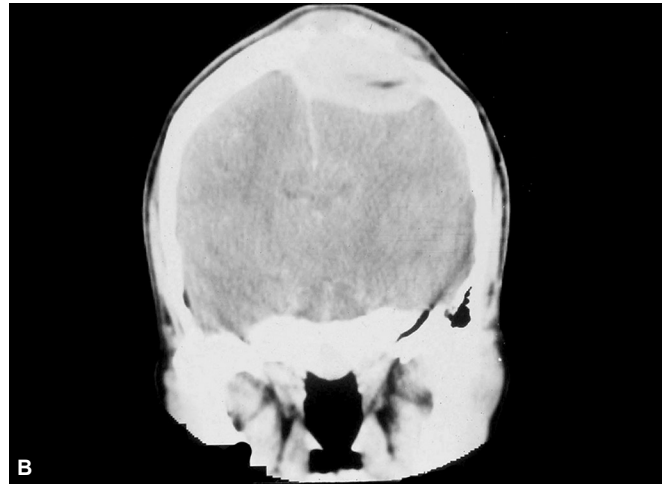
Growing fracture. Posteroanterior (PA) skull radiographs in a child demonstrate fracture of the right frontal bone with thickening, sclerosis and wide separation of the fracture ends. Note the soft tissue swelling overlying this area
